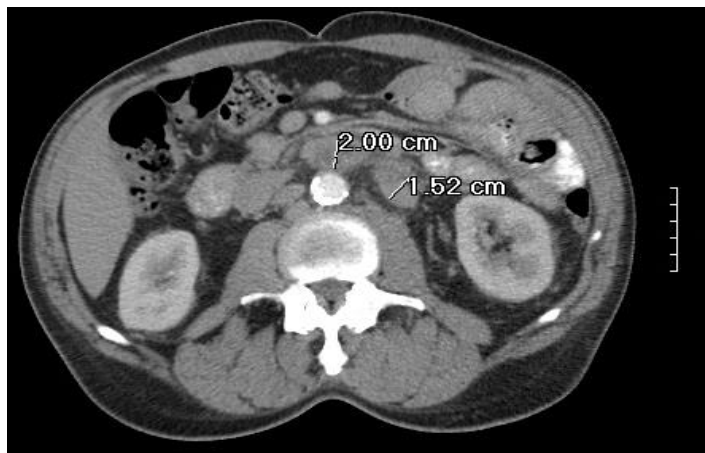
CT pelvis with prominent retroperitoneal lymphadenopathy; the largest nodal masses in the peri-aortic region measuring 2 cm and 1.5 cm
